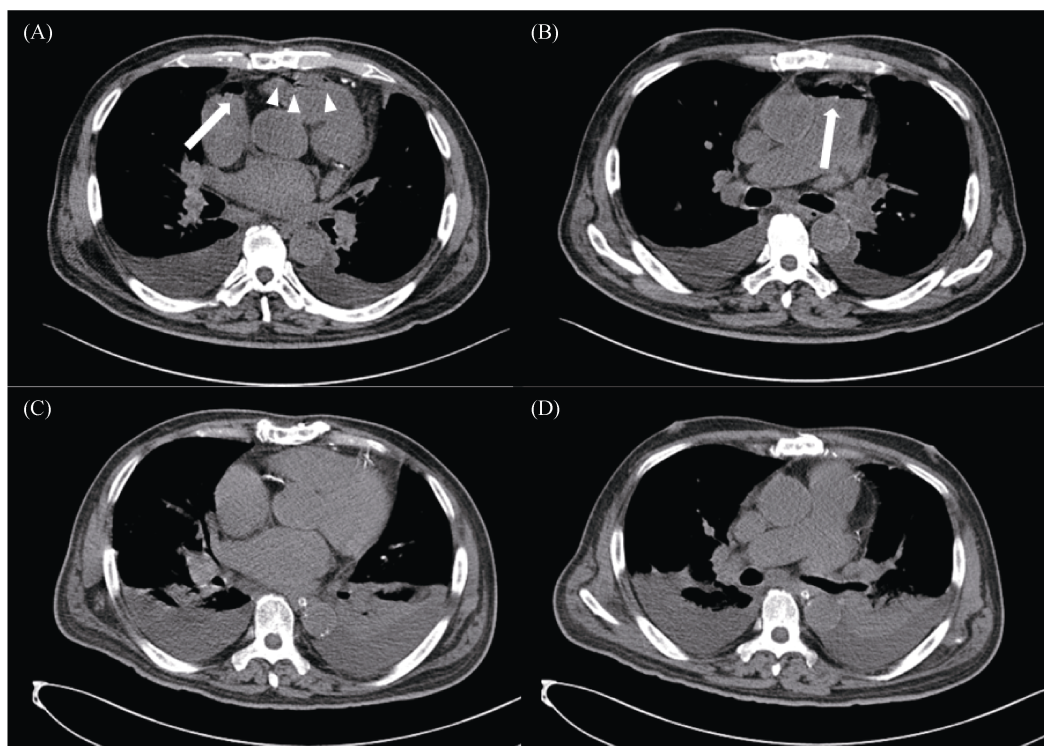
Non-contrast CT scan of the chest in patient with intracardiac air embolism. (A): Axial non-contrast CT shows the presence of free air in the anterior part of the right atrium (arrow) and ventricle (arrowheads); (B): arrow points towards large amount of air in the pulmonary artery; (C & D): after air aspiration, follow-up chest CT demonstrates disappearance of air in the right atrium and ventricle, and pulmonary artery.
